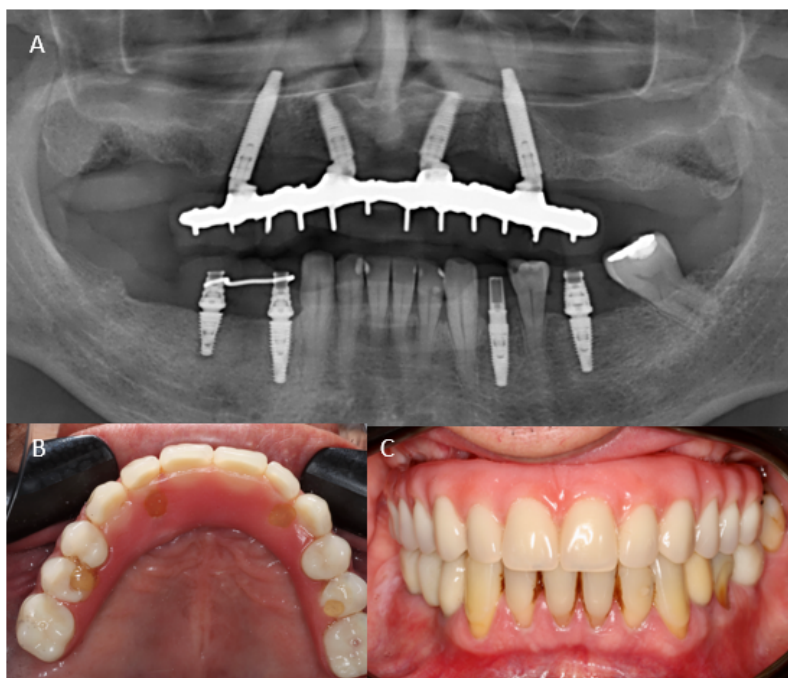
Radiographic(A) and clinical aspects (B-C) after maxillary full-arch immediate rehabilitation and mandibular provisional prostheses
